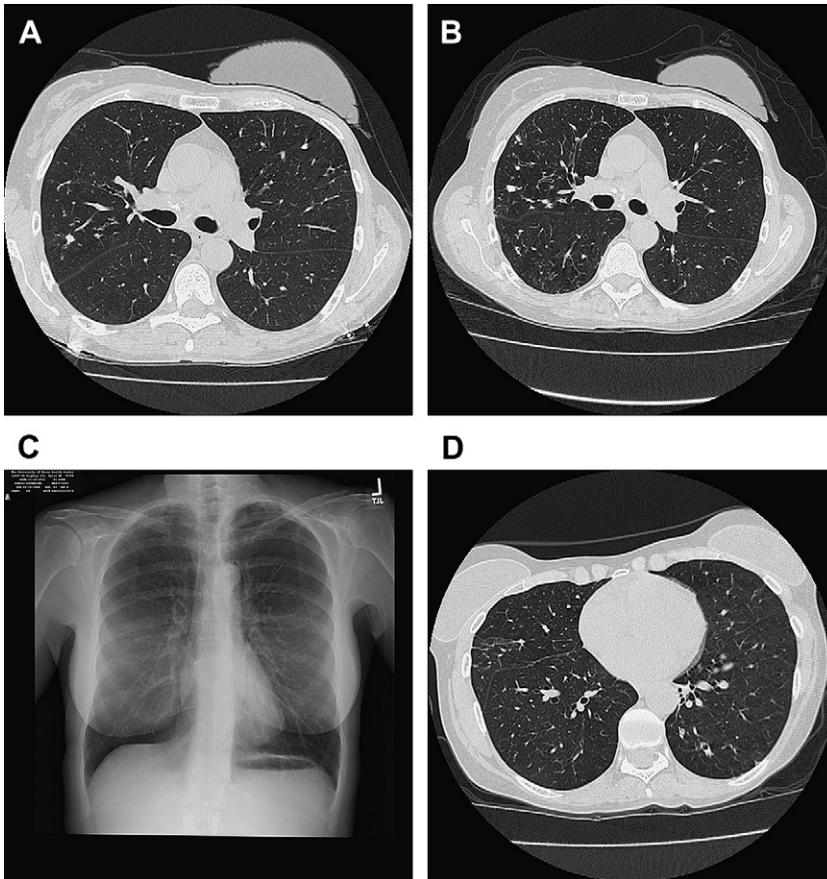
(A) HRCT image of a 62-year-old woman with bronchiectasis and one cystic fibrosis transmembrane regulator (CFTR) gene mutation diagnosed with MAC lung disease before initiation of therapy. (B) Comparable HRCT image after 24 months of treatment for MAC lung disease including 12 months' therapy with a parenteral agent and right middle lobe lobectomy, and with persistently positive sputum AFB cultures for MAC. (C) P/A chest radiograph of a 64-year-old woman with minimal mid-lung field densities before initiating multidrug MAC therapy with a macrolide-based regimen. (D) HRCT image showing minimal right middle lobe tree-in-bud abnormalities from the same patient after 12 months of multidrug macrolide-containing therapy, with sputum still AFB-culture-positive for MAC.
